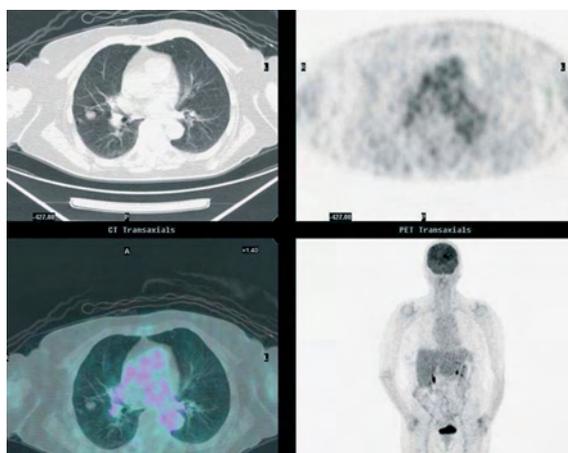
Solitary pulmonary nodule in the right lung without F-18-FDG uptake
